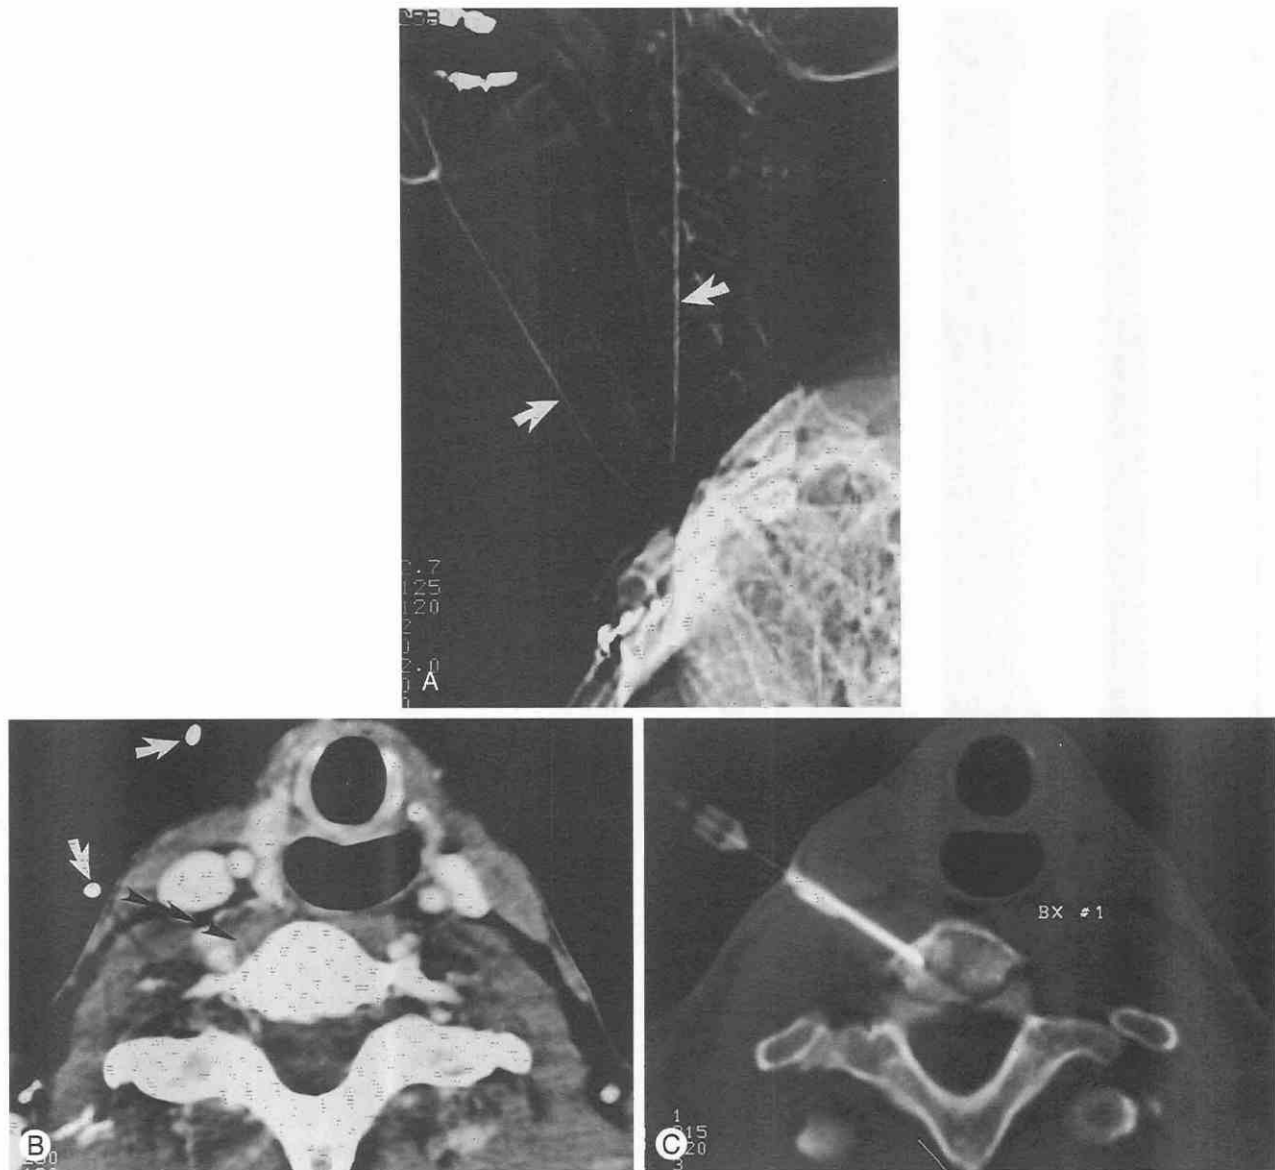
CT-guided biopsy of the cervical spine.
